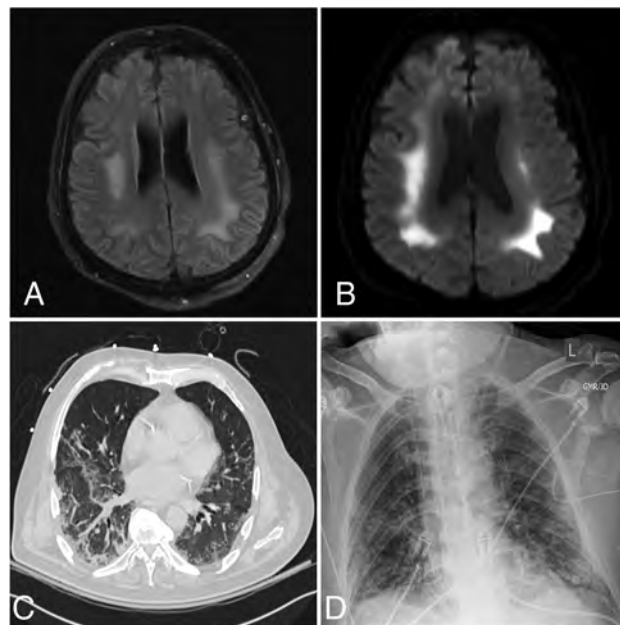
A 64-year-old man presented with fever and shortness of breath. Axial FLAIR (A) and diffusion-weighted (B) images demonstrate extensive symmetric confluent T2/FLAIR signal abnormality and restricted diffusion involving the corona radiata bilaterally. C, Chest CT shows bilateral peripheral ground-glass opacities and a small amount of consolidation involving all lobes, with a CCS score of 15. D, Portable chest radiograph demonstrates bilateral lower-zone-predominant peripheral opacities with a PXS score of 8.8.
